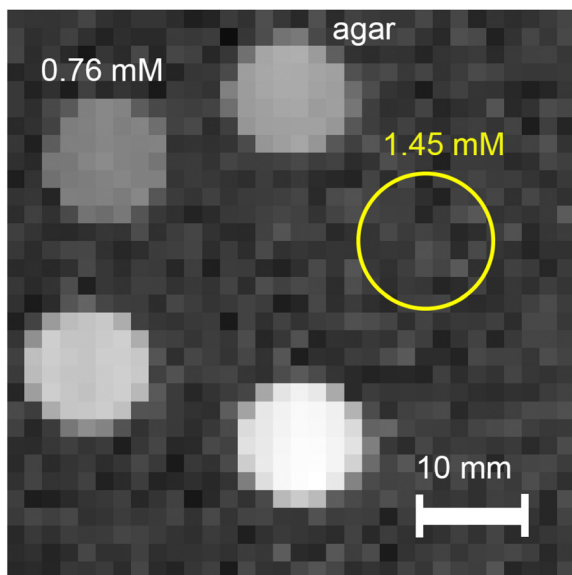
MR imaging in the field of 0.2 T and at 23 °C using the spin-echo sequence. Yellow circle marks area of the location of 1.45 mM concentration sample. Due to short  $T_2$  and long TE, signal from water hydrogen proton in this area is not visible. Longer  $T_2$  of concentration 0.73 mM, allows the sample visualization.
